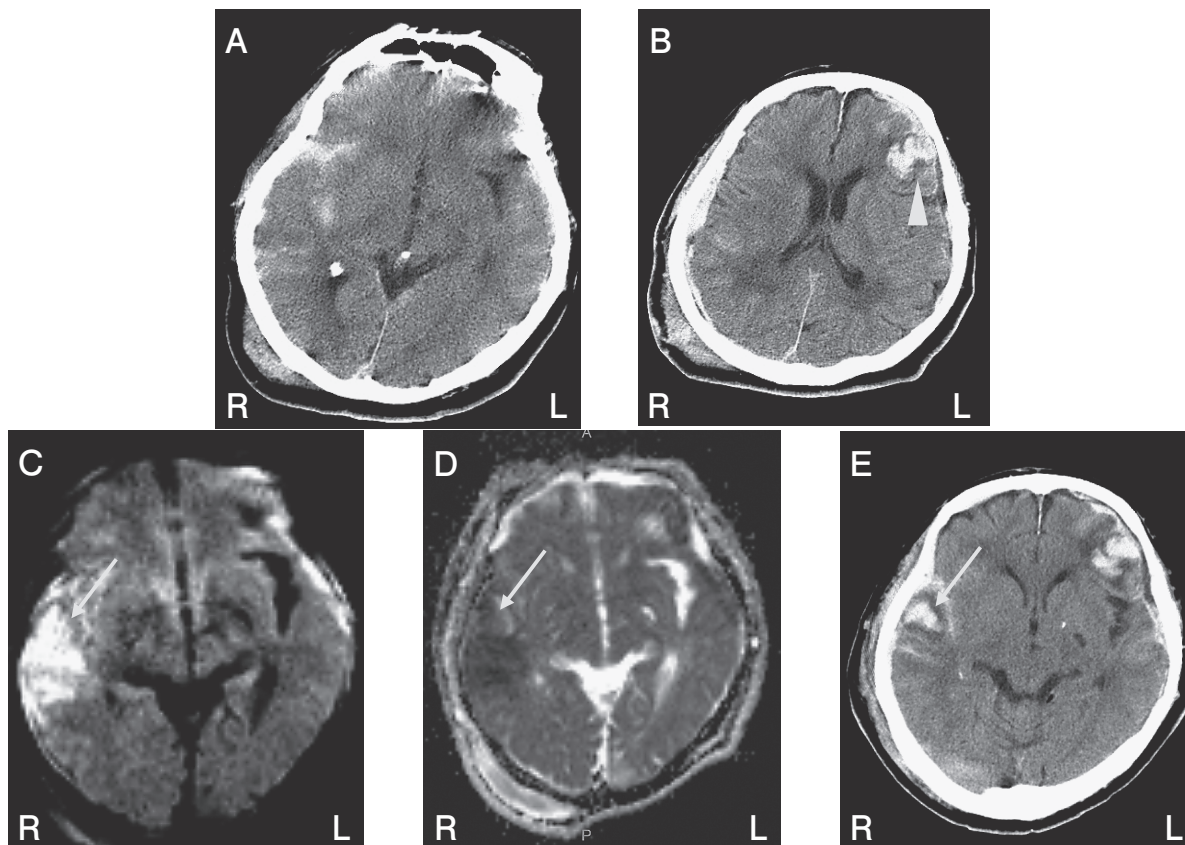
Brain CT at the previous hospital revealed subarachnoid hemorrhage, but intracerebral hematoma was not detected. Repeat CT just after the patient was transferred to our hospital detected new appearance of hematoma in the left frontal lobe (A and B arrowhead) and a diffusion-weighted image revealed a high-intensity lesion in the right temporal lobe, which was considered to be a CT-DWI mismatch because CT did not detect high-density lesions in the right temporal lobe (C arrow). The ADCs decreased where the CT-DWI mismatch was detected (D arrow). Repeat CT obtained on the following day showed a new appearance of intracerebral hematoma in the same region where the CT-DWI mismatch was detected (E arrow).
